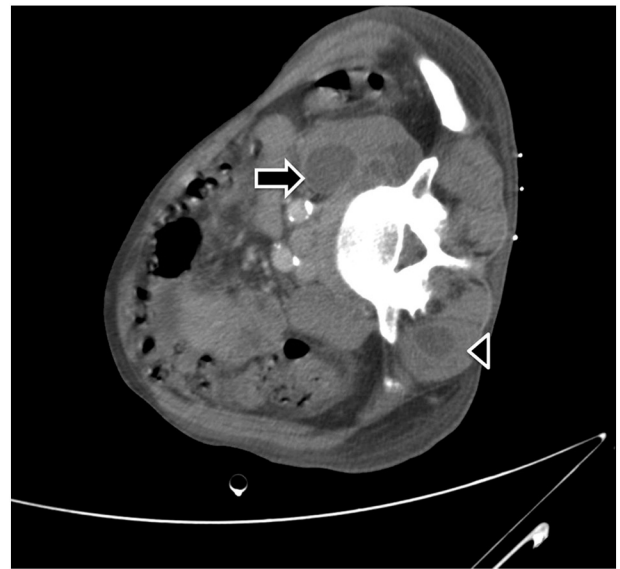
Abdomen CT showed a low-density mass at the left psoas muscle (arrow) and a hypodensity lesion over the right longissimus muscle (arrowhead).
